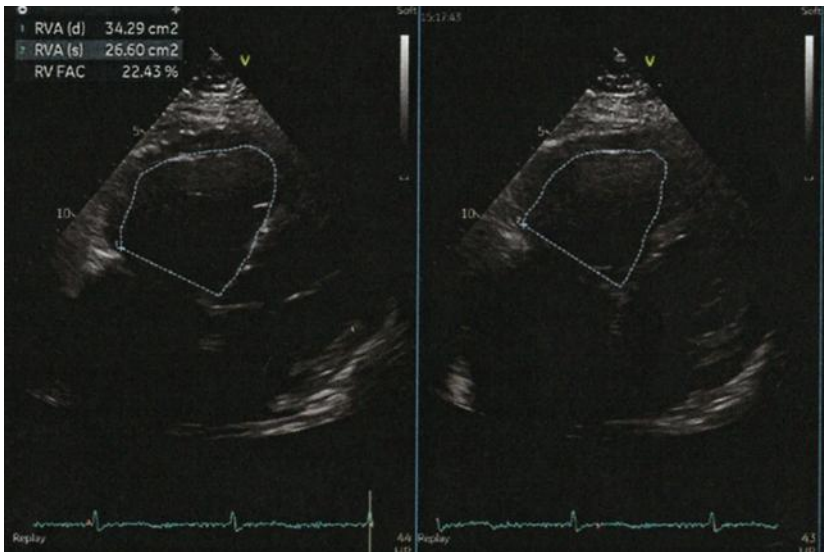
A right ventricular fractional area change of 22.43% is seen on echocardiography
